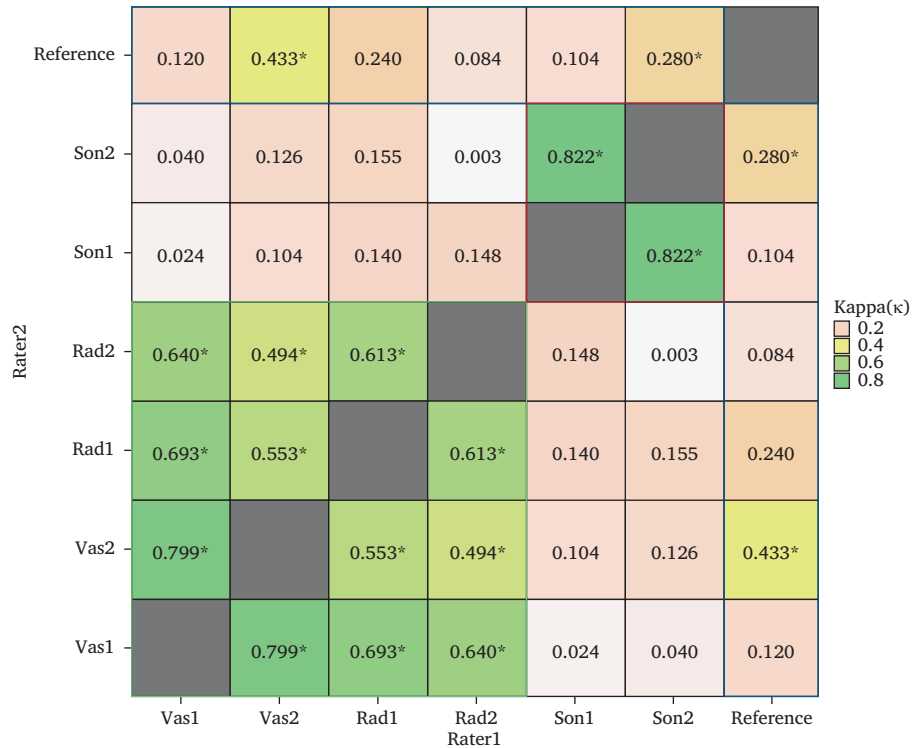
Concordance for arterial thoracic outlet syndrome between all raters. Blue box: rater concordance against reference. Red box: concordance between ultrasound raters. Green box: concordance among digital subtraction angiography) raters. *Values of concordance that are significantly different from $\kappa = 0$. Vas = vascular surgeon; Rad = radiologist; Son = sonographer.
